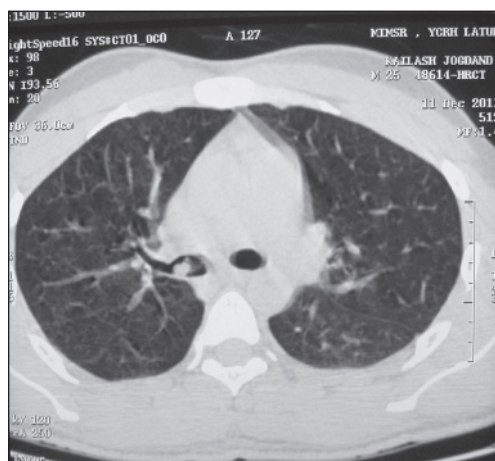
CT thorax Lung window - showing growth with stem of attachment at posterior wall without obvious abnormality in lung parenchyma
